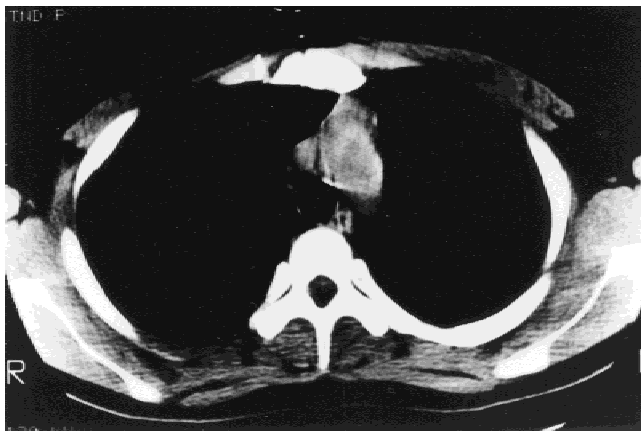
CT scan of the chest. Pretreatment chest CT scan Demonstrating (A) anterior mediastinal tumor and (B) normal posttreatment chest CT scan.
